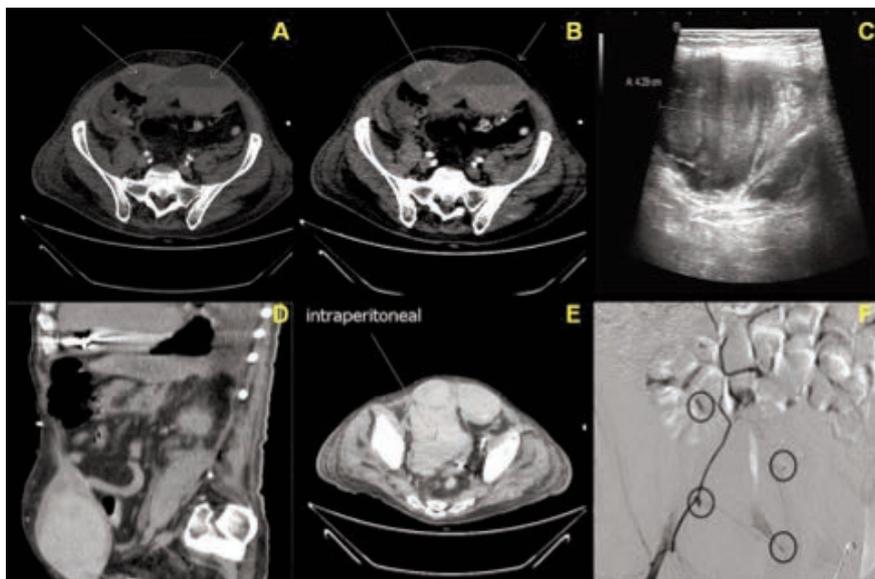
Computed tomography (CT) imaging of the bilateral rectus sheath hematomas (RSHs) of patient #2. He was 72 years old with a known cardiac ischemic disease (ejection fraction 25%), and he was admitted for a persistent atrial fibrillation. Low-molecular-weight heparins (LMWHs) and warfarin were initiated. After 2 days there were periumbilical and flank ecchymosis at the sites of LMWHs injections due to RSHs (A with intraperitoneal extension (white arrowhead). RSHs were complicated from an abdominal compartment syndrome and acute renal failure. CT images of RSHs without and with contrast (A and B). Ultrasound image of one RSH (C). Abdominal sagittal plane (D) and intraperitoneal expansion of RSH (E). Angiography of the right epigastric artery with several bleeding points encircled (F).
